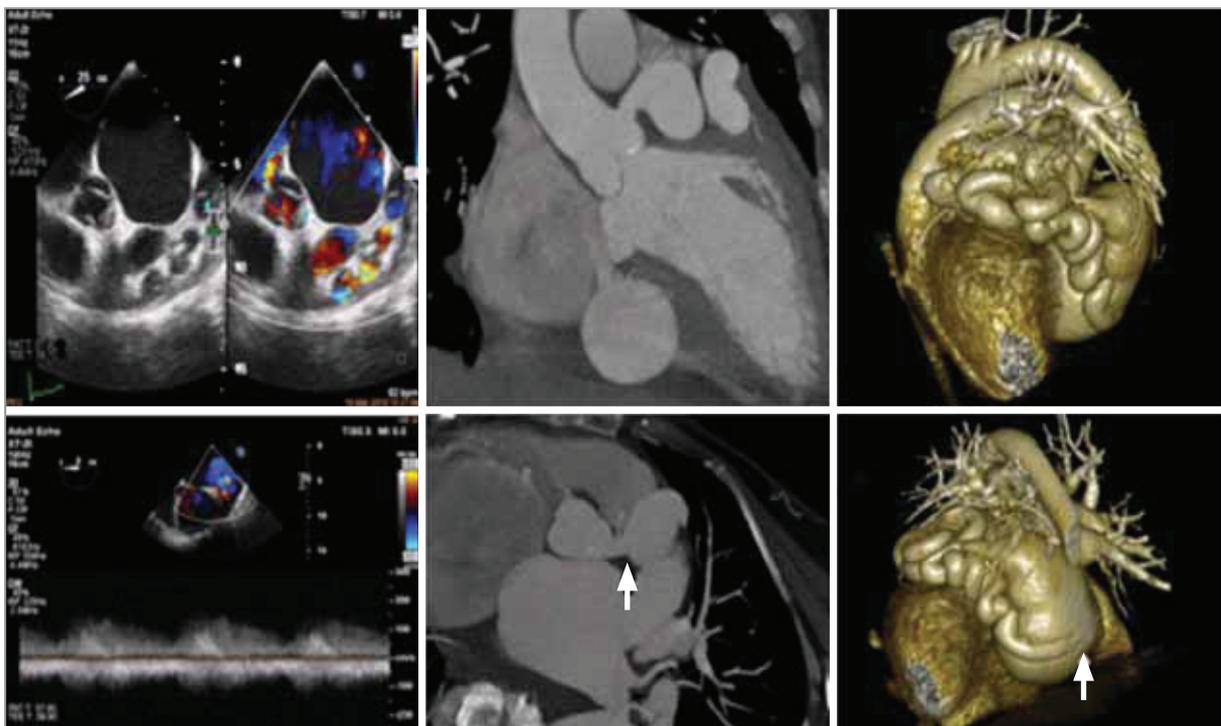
Multimodality imaging of a patient with giant circumflex artery aneurysm (arrows) with Trans-oesophageal echocardiography (far left, top and bottom) showing beaded appearance on cross-section with continuous flow and cardiac computed Tomography (middle top and bottom panels and far right top and bottom panels) delineating the origin and drainage of the aneurysm through a fistula into the coronary sinus.
